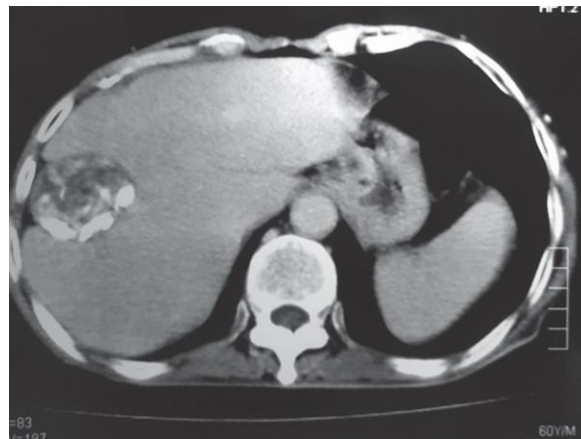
CT scan abdomen showing hydatid cyst in right lobe of the liver
